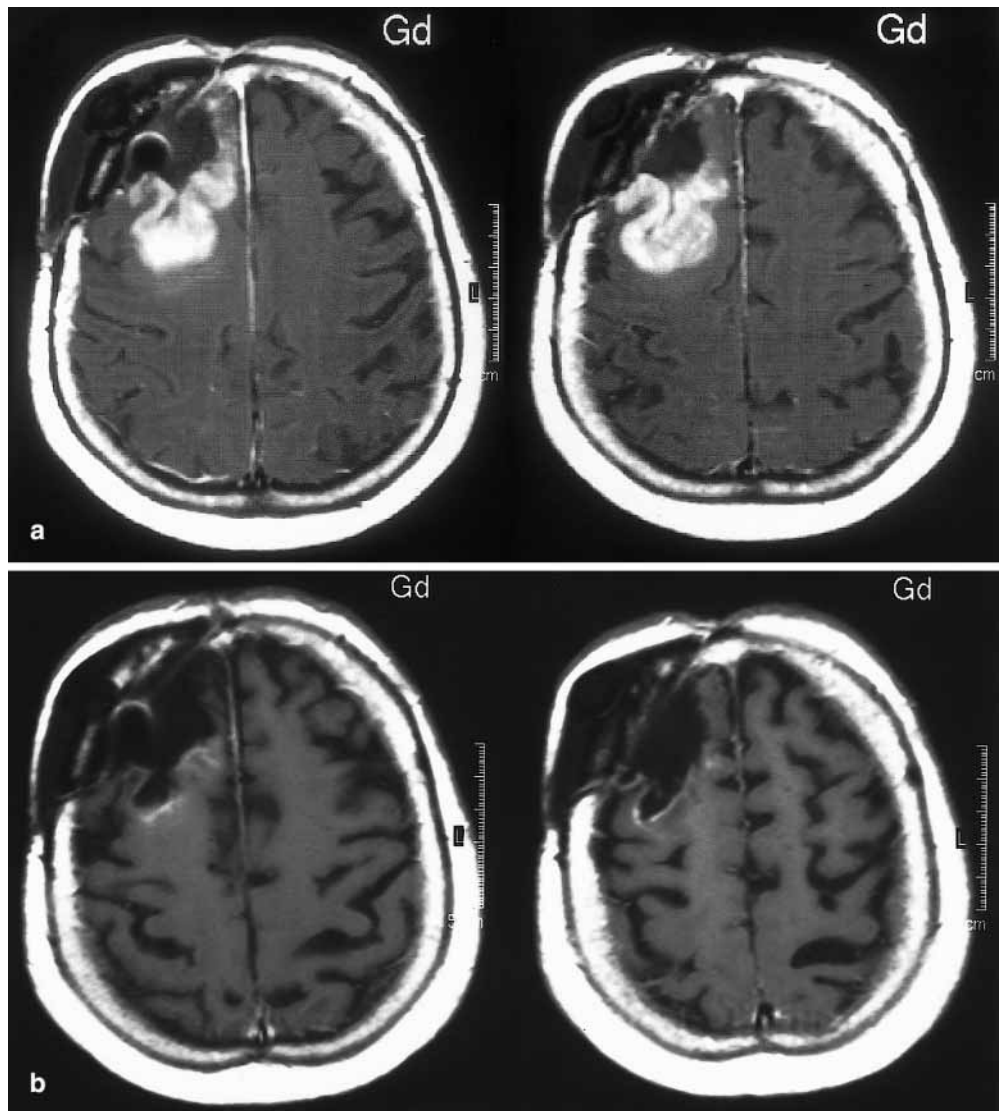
a Patient no. 95, female, 57 years old. The patient was operated on in February 1998, and then received radiotherapy (59 Gy). However, in January 1999 she underwent a further operation owing to disease relapse. During surgery an indwelling catheter was inserted. She received 6 cycles of local radioimmunotherapy (cumulative ^{90}Y dose 3936.8 MBq, corresponding to 106.4 mCi). MRI, performed in June 1999, demonstrated a huge tumour mass which was growing in spite of two cycles of infusion of radioactive antibodies. b Following four courses of radioimmunotherapy the tumour volume is significantly decreased
